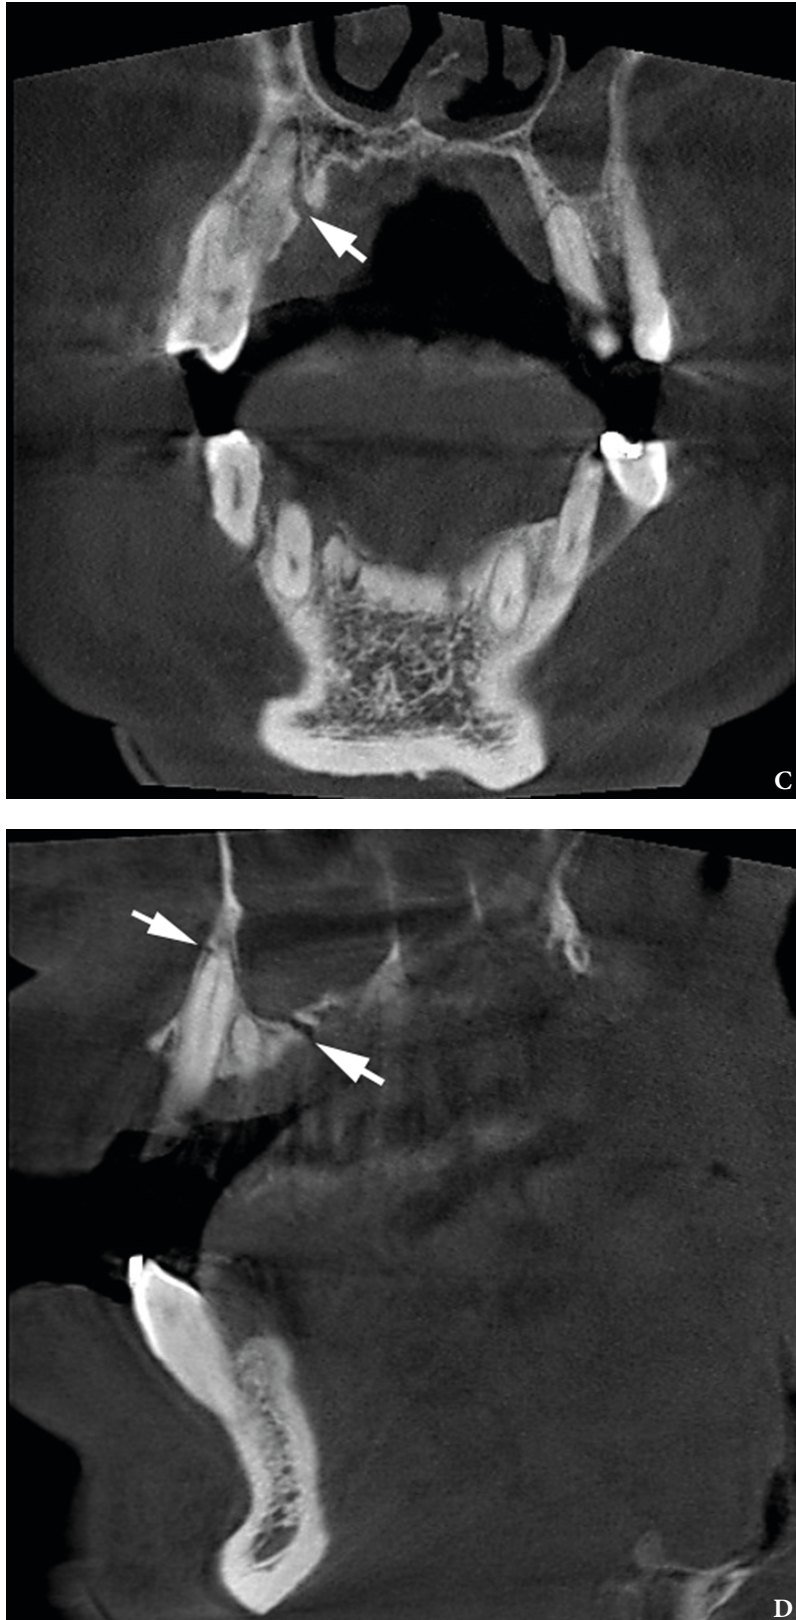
(cont'd). A coronal (C) and sagittal (D) CBCT scans shows no roots fracture of the teeth 1.3-1.5. The CBCT confirmed only a maxillary alveolar fracture (arrows). Images of Figure 3 are courtesy of *Ievgen I. Fesenko, PhD, Assis Prof; Kyiv, Ukraine.*
